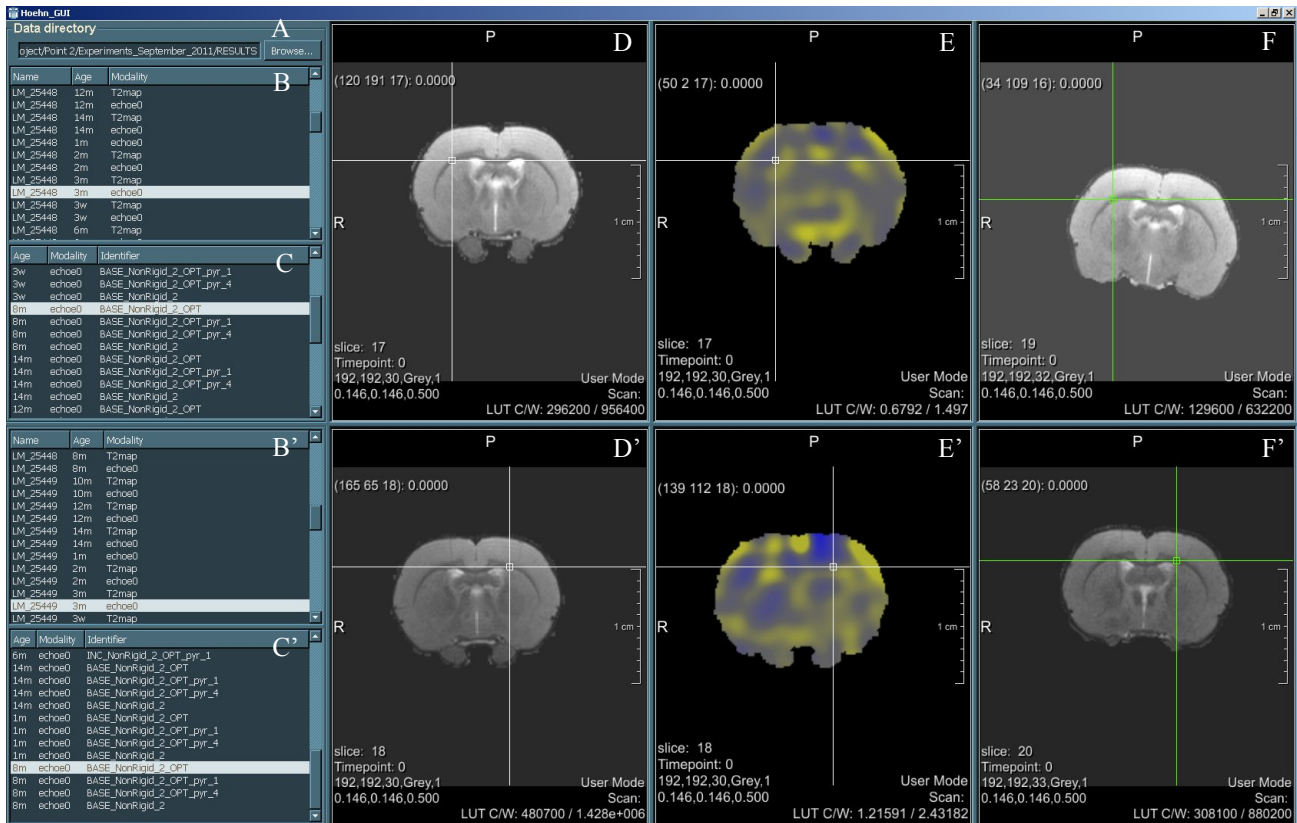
A screenshot of the proposed visualization platform for co-registered high-throughput multi-contrast, follow-up, cross-sectional MRI brain data exploration. Once the main directory is defined in (A), (B) presents a list with all the available data: different subjects acquired using different modalities in different time-points. This list can be sorted according to subject name, age or modality. After a baseline dataset of interest is selected in (B) a list of all the datasets co-registered to it (other subjects, modalities, types of experiment) is presented in (C). This way a quick overview of the co-registered data is available. The view panel (D) shows the selected baseline from (B), and panel (F) shows the dataset of interest that was previously co-registered to the selected baseline. These 2 datasets of interest are now
